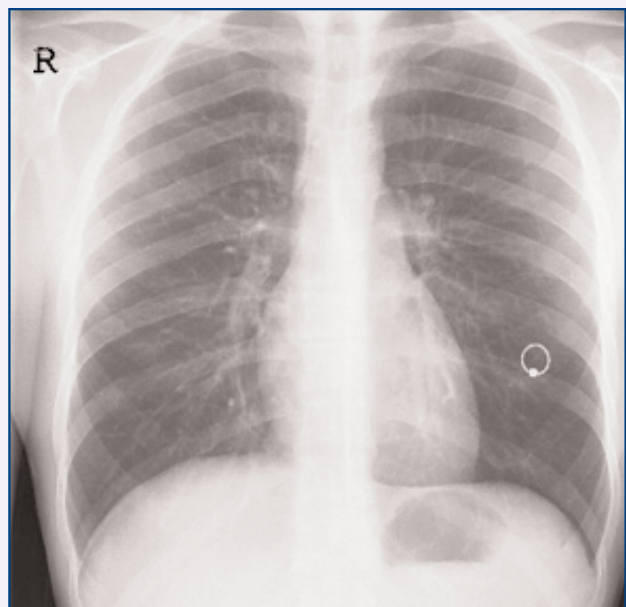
Michael's X-ray.
